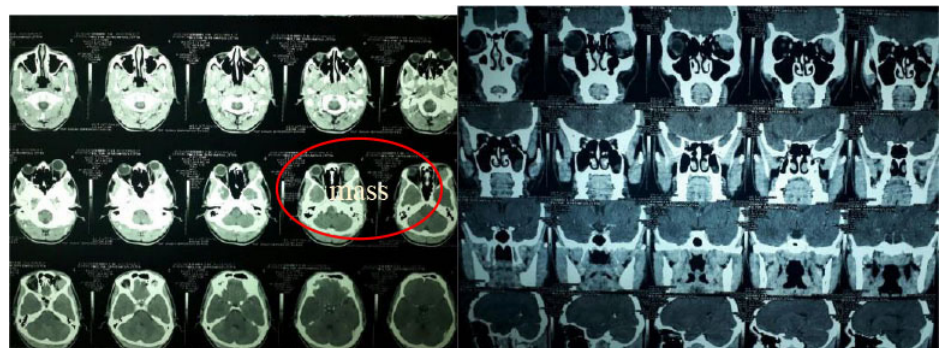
CT Scan from the Johannes Kupang Hospital, CT scan of the head of the axial and coronal slices, without and with contrast when first arrived in 2017.
